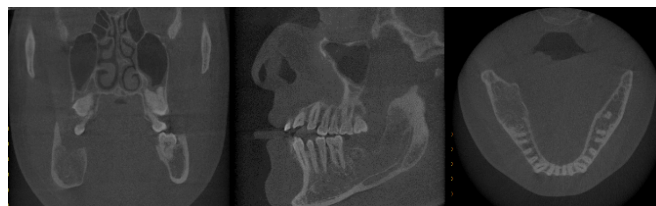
Postoperative 1-year follow-up ongoing bone healing on CBCT.
